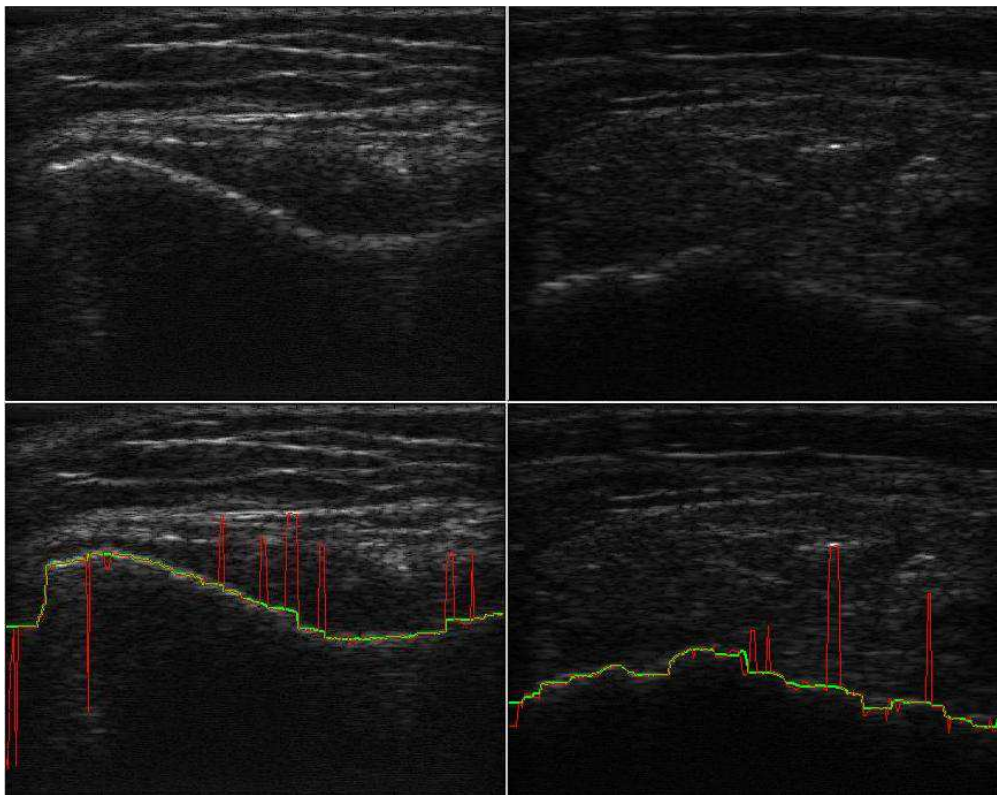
Two ultrasound B-mode images (top), and the extracted bone contour from their RF data overlaid on the B-mode images (bottom). The unfiltered contours are shown in red, and the median-filtered contours, to filter the outlier echoes, are shown in yellow
